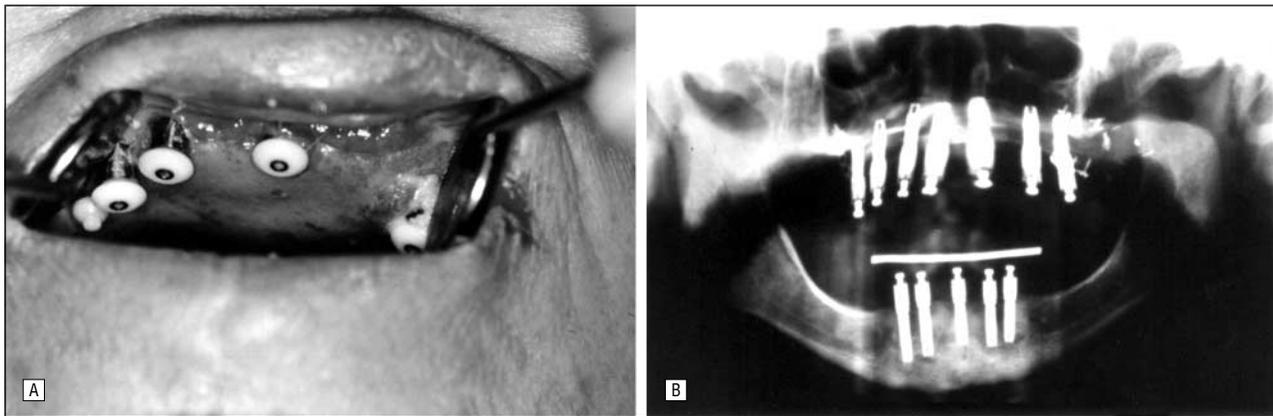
A, Osseointegrated implants in place 5 months after primary procedure. B, Panoramic radiograph after implant placement.
